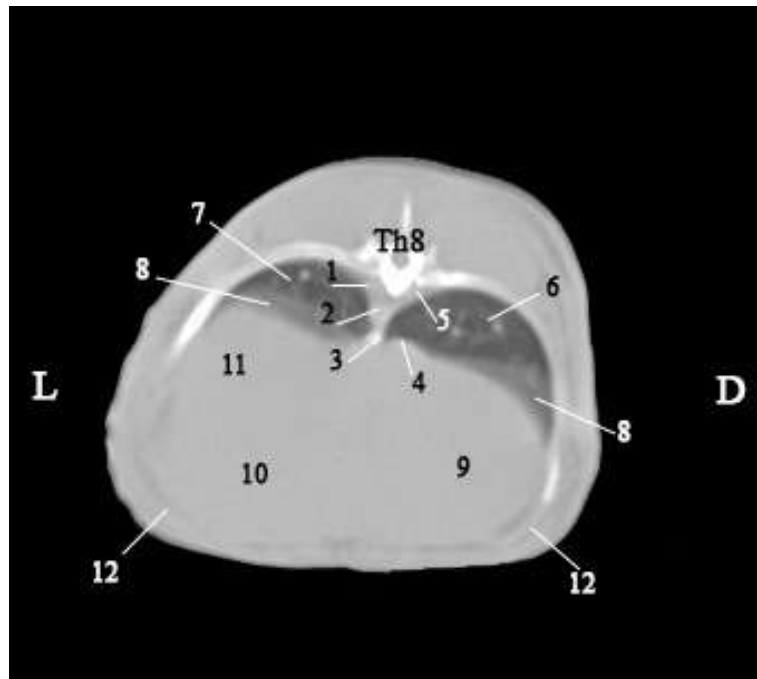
Transversal helical anatomical CT image of cranial abdominal region. (L-left, D-right) (abdominal recumbency). (1) left azygos vein; (2) abdominal aorta; (3) oesophagus; (4) caudal vena cava; (5) right azygos vein; (6) right lung; (7) left lung; (8) diaphragm; (9) right lobe of liver; (10) left medial lobe of liver; (11) left lateral lobe of liver; (12) abdominal muscles.
